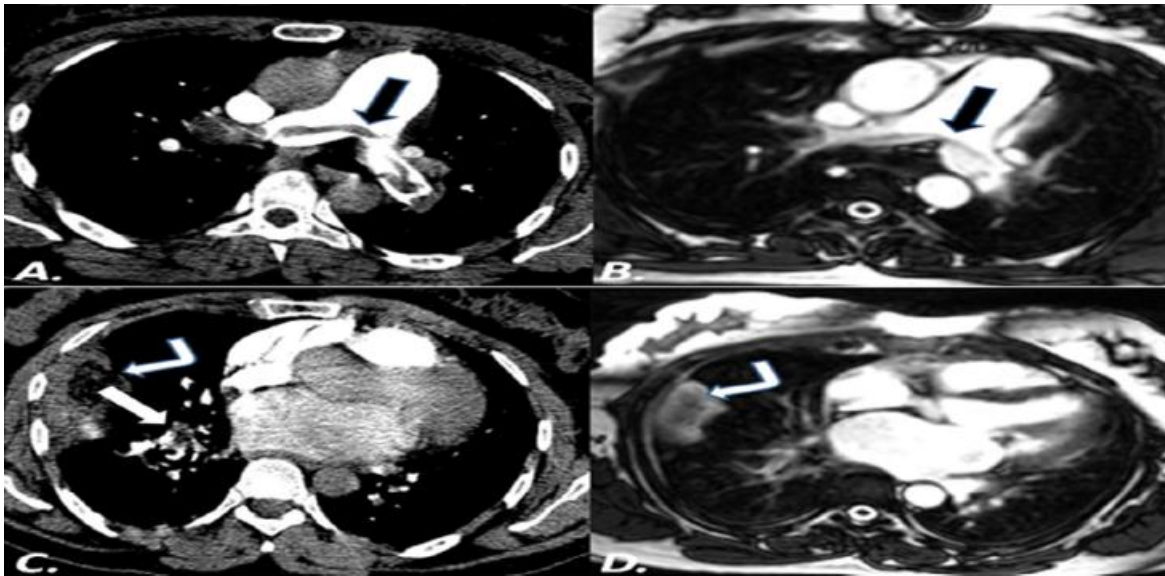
A female patient 47 years old presented with dyspnea and chest pain. (A) And (C) Axial CT image demonstrates pulmonary embolism totally occluding the right main pulmonary artery. Also, a totally Occluding one noted involving the segmental branch of the right upper lobe division (arrow). (B) and (D) Axial MR-PA-WB taken 48 h later reveals the right main pulmonary embolism appearing as a hypointense filling defect (arrow) yet partially occluding the lumen. The embolism involving the segmental branch of the right upper lobe division couldn't be demonstrated in MR-PA as in CTA.
